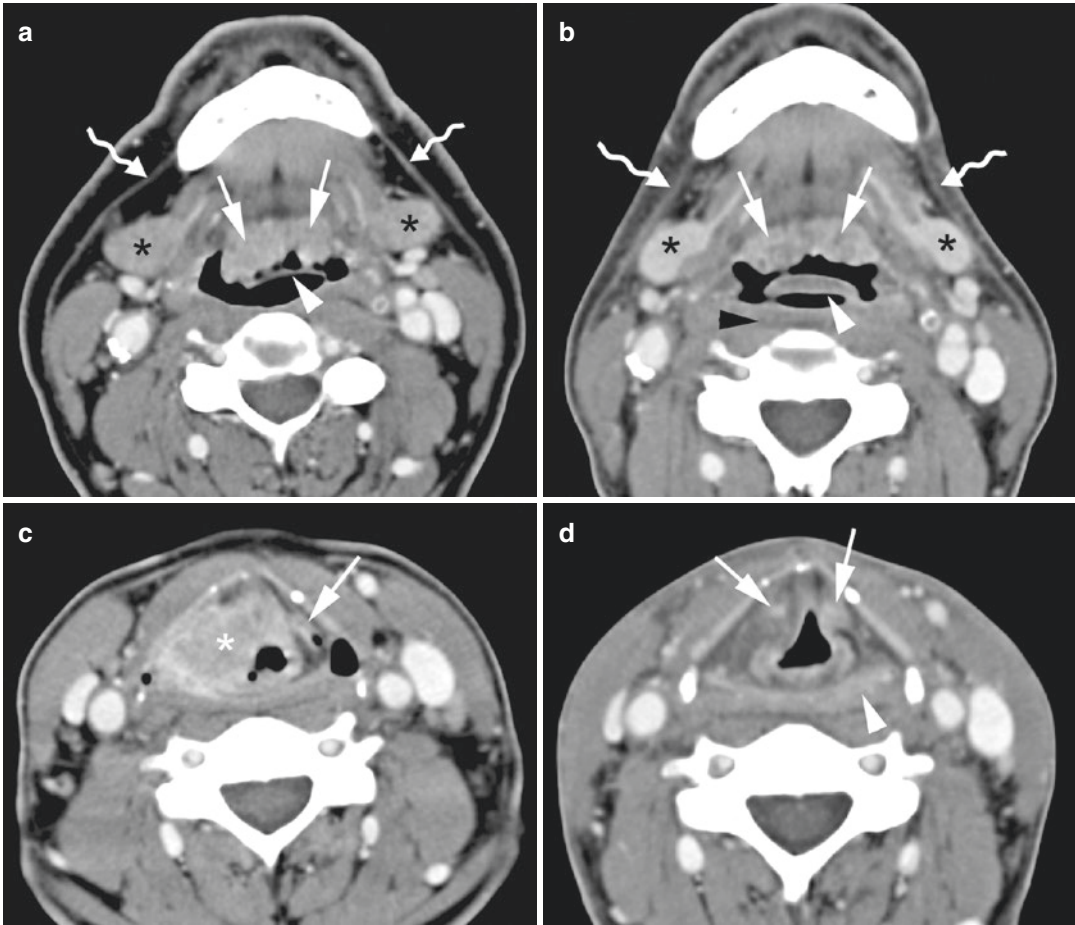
Patient with supraglottic squamous cell carcinoma, staged T3N0, treated by definitive radiotherapy. Axial contrast-enhanced CT images are shown, obtained just before and 3 months after completion of radiation treatment. (a, b) Level of lingual tonsil. After radiotherapy (b), apart from diffuse increased attenuation of the neck fatty tissue, thickening of the free edge of the epiglottis (white arrowhead), platysma muscles (curved arrows), and oropharyngeal walls is seen. Slight amount of retropharyngeal edema is present (black arrowhead). Note also increased enhancement of the submandibular salivary glands (asterisks), corresponding to radiation
